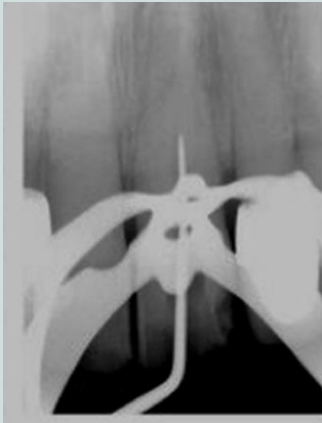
Periapical of 26
